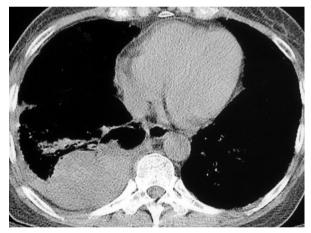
Chest CT revealed a right lower lobe consolidation, with a longest diameter of about 9 cm.
